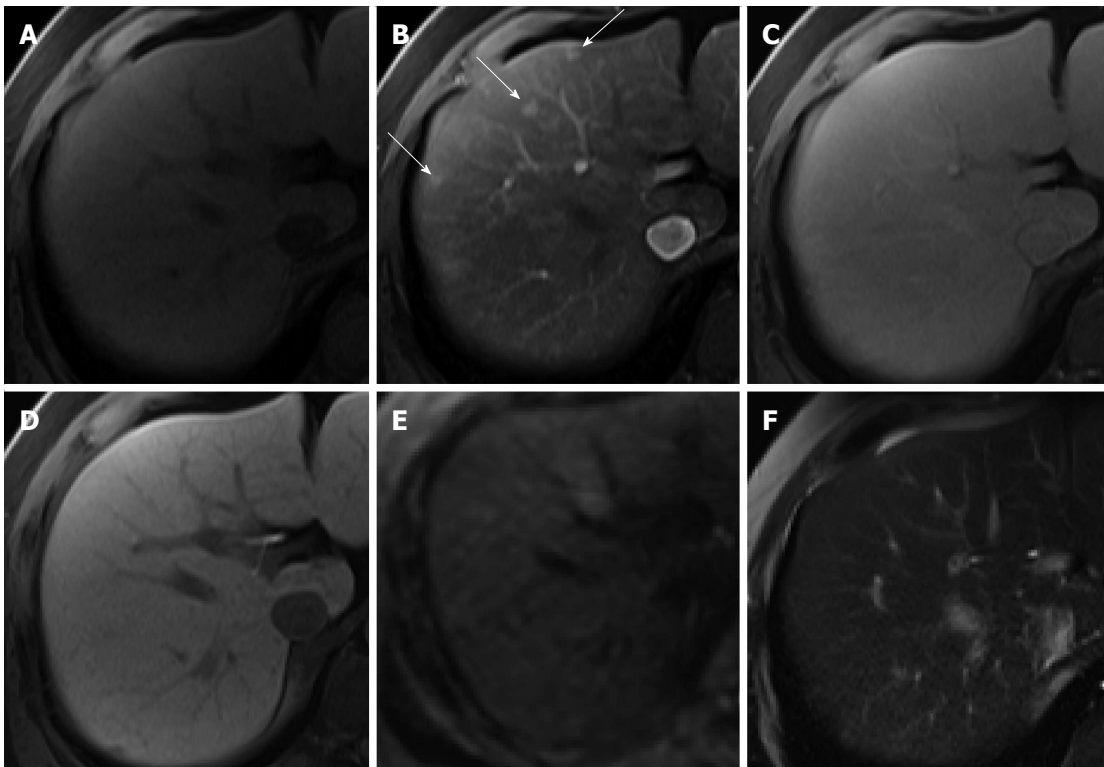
Hypervascular pseudolesion in a 49-year-old man with normal liver. A: Precontrast T1-weighted image shows no focal hepatic lesion; B: Hepatic arterial phase using gadoxetic acid shows several arterial enhancing nodular lesions in the liver (arrows); C-F: Transitional, hepatobiliary, T2-weighted, and diffusion weighted images show no signal change.
